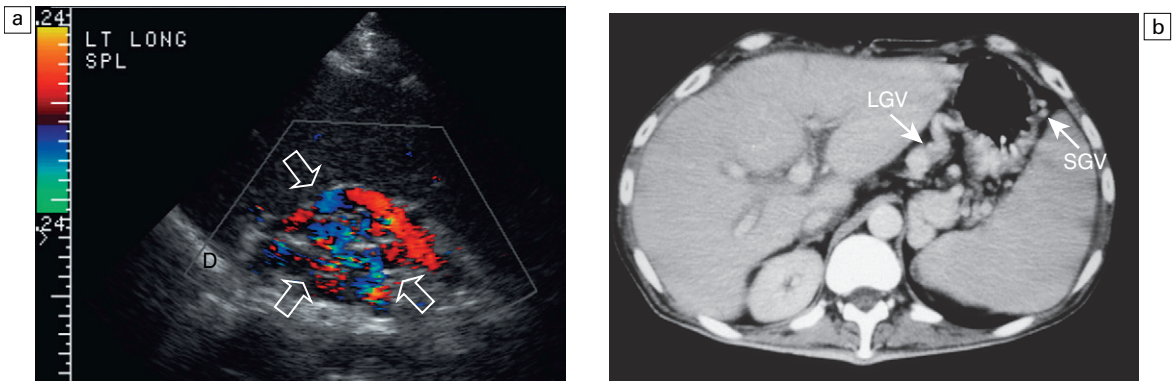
(a) Longitudinal colour Doppler view of the left flank in a patient with portal hypertension. A tangled web of vessels (arrows) is seen at the splenic hilum and extends cephalad towards the diaphragm (D). These are short gastric varices coursing from splenic veins to the stomach and from there to the systemic circulation via esophageal varices. (b) Contrast-enhanced CT of a patient with portal hypertension. Short gastric varices (SGV) are best imaged from the left flank using the spleen as a sonographic window. The left gastric varix (LGV) is best imaged through the left lobe of the liver.
